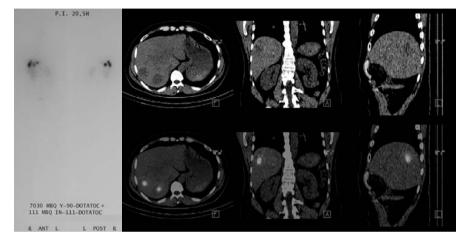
Patient with neuroendocine tumor and liver metastasis. Irradiation with 111 In- / 90 Y-DOTATOC. Planar scintigraphic imaging on the left side, SPECT/CT fusion imaging on the right side of the picture.
